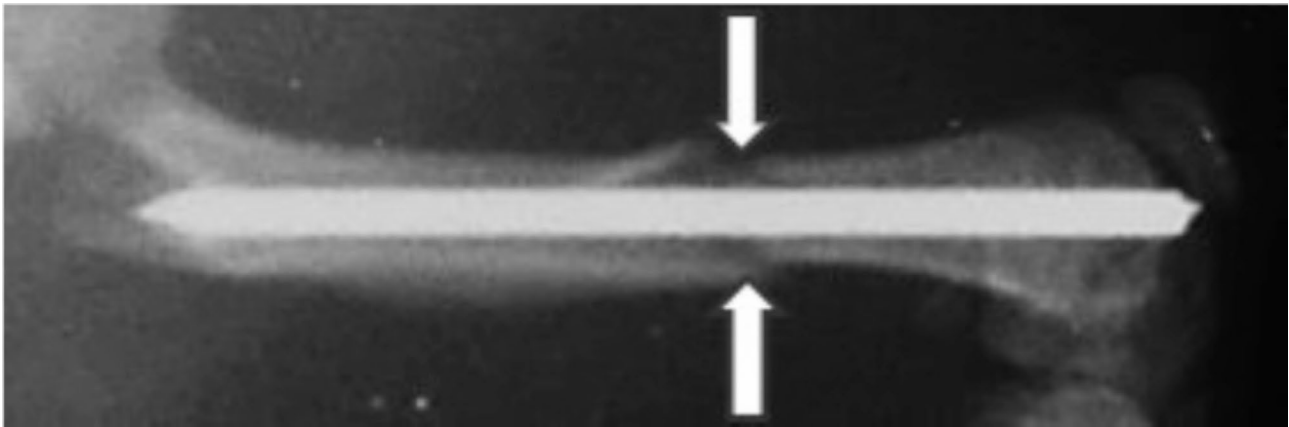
The X-ray of the femur which was taken immediately after producing the fracture model. White arrows indicate the fracture line
